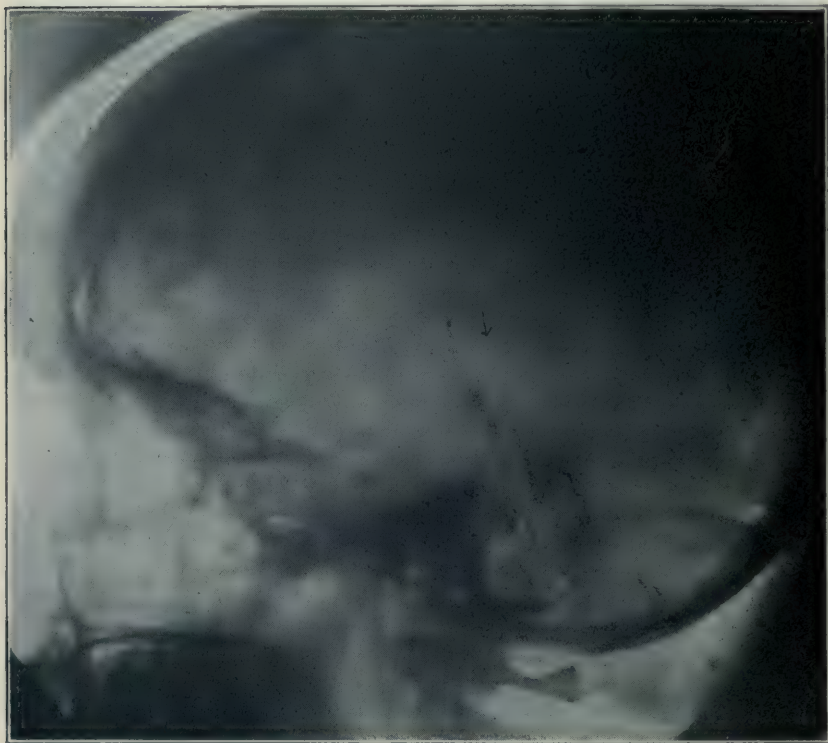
Roentgenogram of skull of patient 27 (Fig. 11), a girl 19 years of age. Here the shadow is not so distinct as in the others, but still is present.
